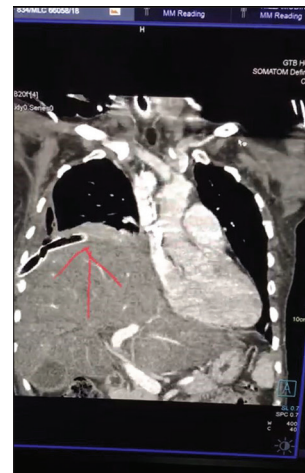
Contrast-enhanced computed tomography thorax film of the patient
